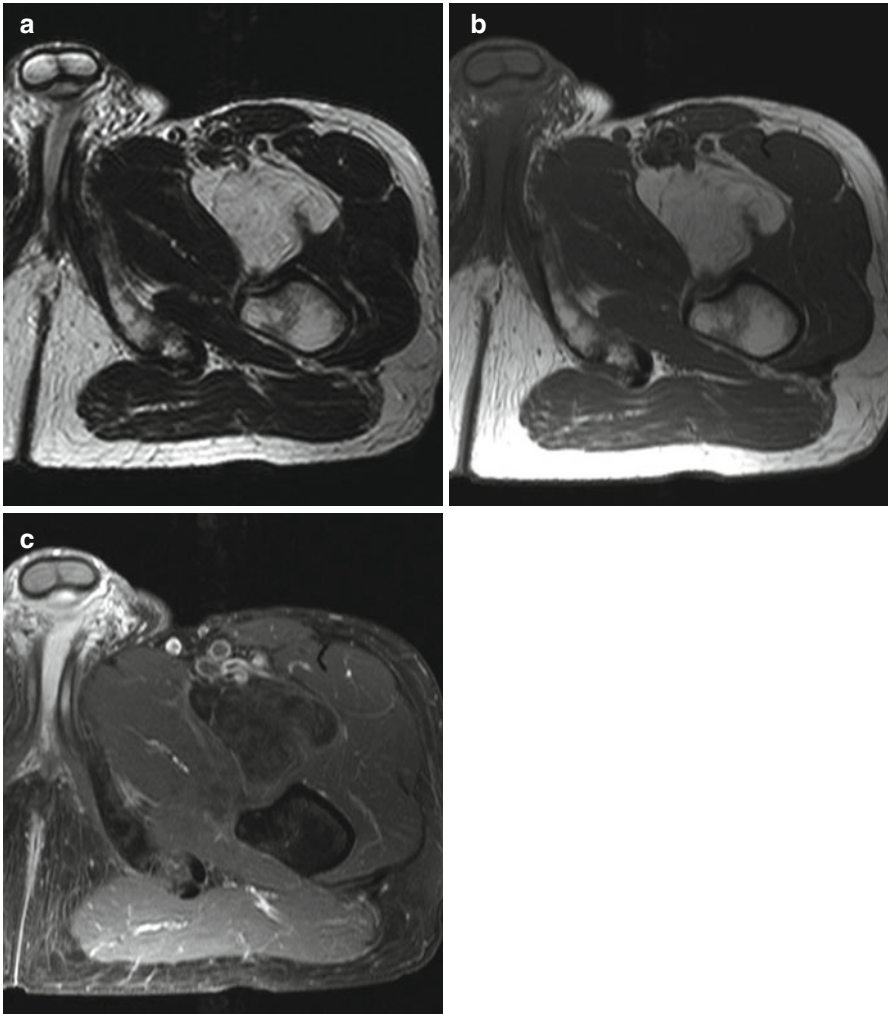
Diagnostic workup (same subject as Fig. 10.32) with contrast-enhanced MRI allows differentiation of a simple lipoma from liposarcoma. Only a liposarcoma will enhance after IV contrast medium administration. Precontrast axial T1w TSE image (a) and axial T2w TSE image (b). The lesion does not enhance on postcontrast axial fat-suppressed T1w TSE image (c), confirming lipoma
